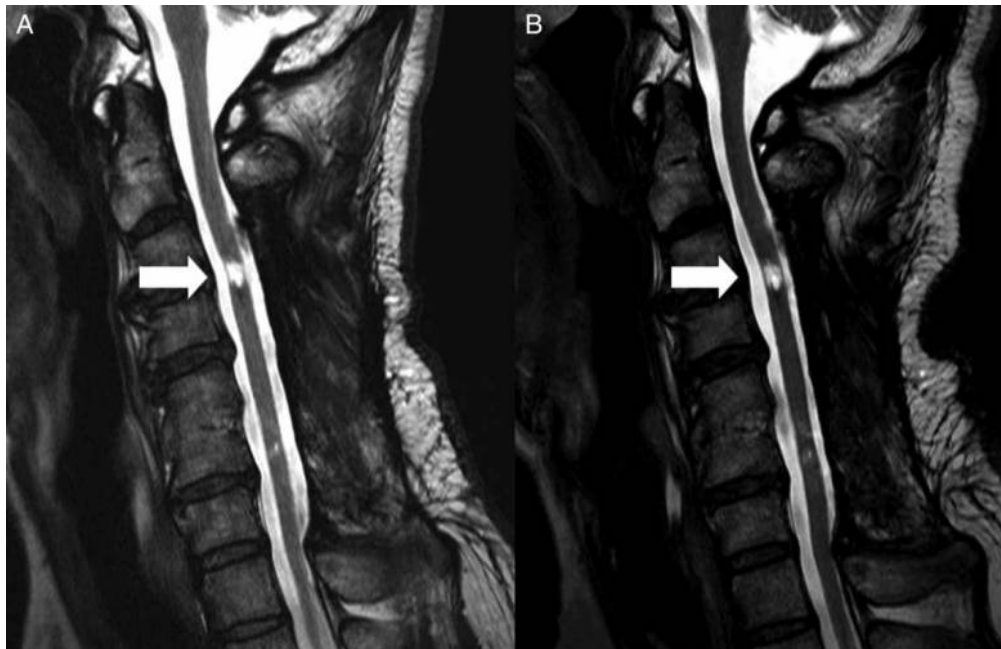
T2 sagittal MR image of patient 14. There was no interval change between baseline (A) and 8 months after transplantation (B).
